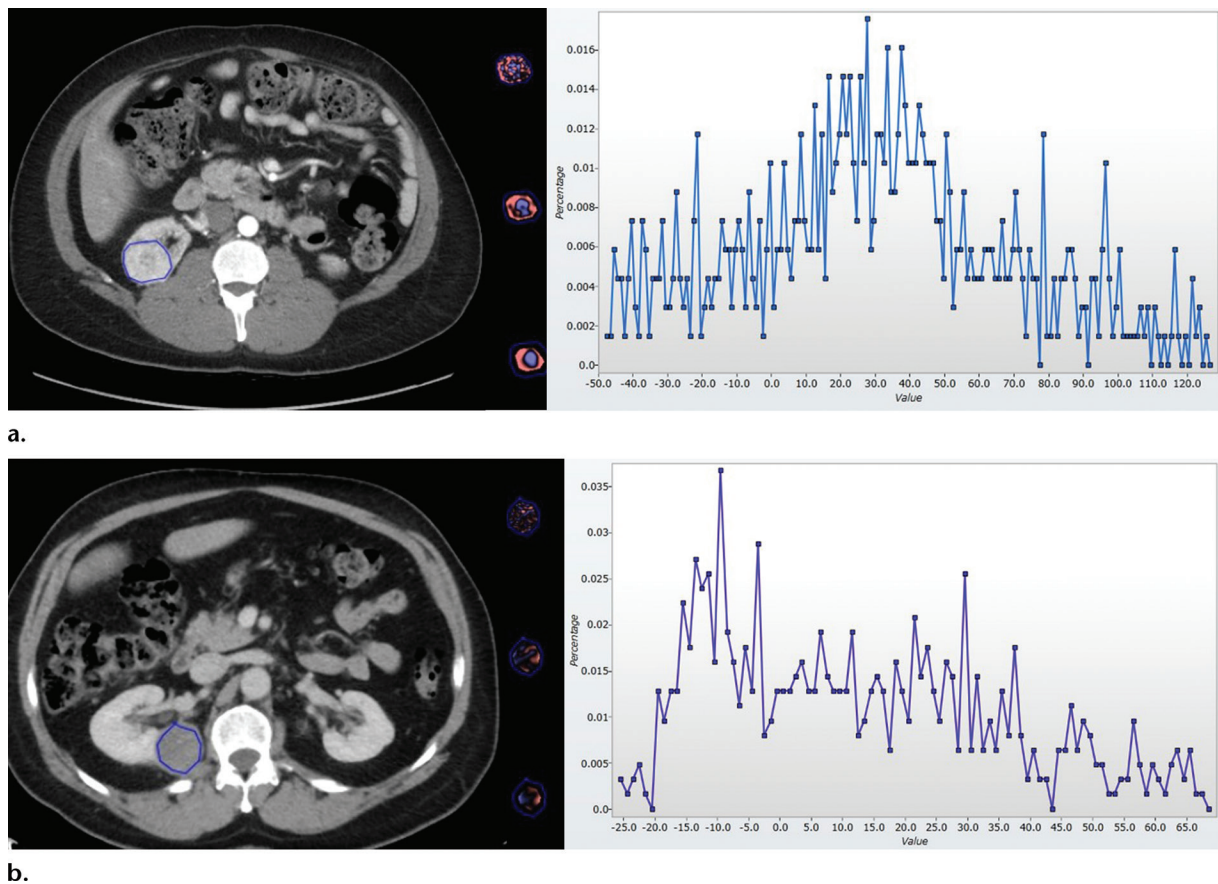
Renal lesions with differences in heterogeneity that can be quantified and used to differentiate lesion types. (a) Left: CT image shows a medium clear cell RCC (blue outline). Middle: Filtered images with color overlay obtained with fine (top), medium (middle), and coarse (bottom) filters. Right: Pixel histogram. With the coarse filter, the lesion shows entropy of 4.9, mean gray-level intensity of 30.4, standard deviation of 39.2, and MPP of 45.77. (b) CTTA of a papillary RCC (blue outline) with associated filtered images and pixel histogram. The lesion shows entropy of 4.32, mean gray-level intensity of 12.4, standard deviation of 22.55, and MPP of 25.7. It is visually and texturally different from that in a: less heterogeneous and generally low in attenuation. (*Continues*)
